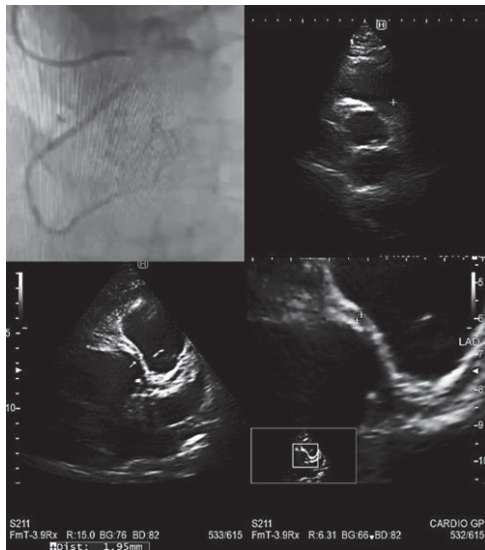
Coronary angiogram revealed abnormal RCA origin and echocardiography identified it to be from the left sinus with initial intramural course. Computed tomography confirmed this diagnosis and the patient was referred to as stress scintigraphy
